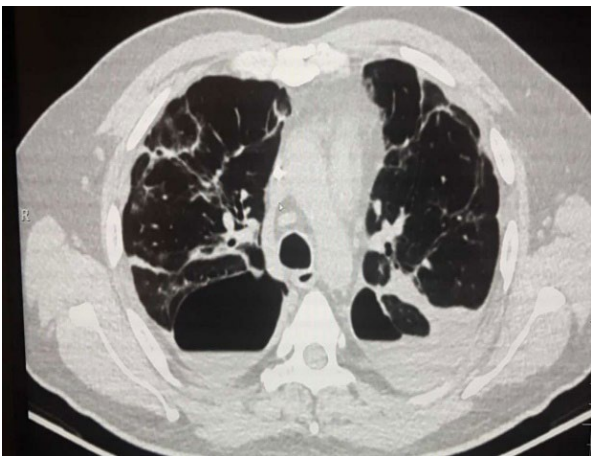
Computed tomography – November 6, 2020 – excess fluid in pleural cavities R-1.8 cm, L 1.6 cm; both cavities contain air constituting a single fluid/gas layer
